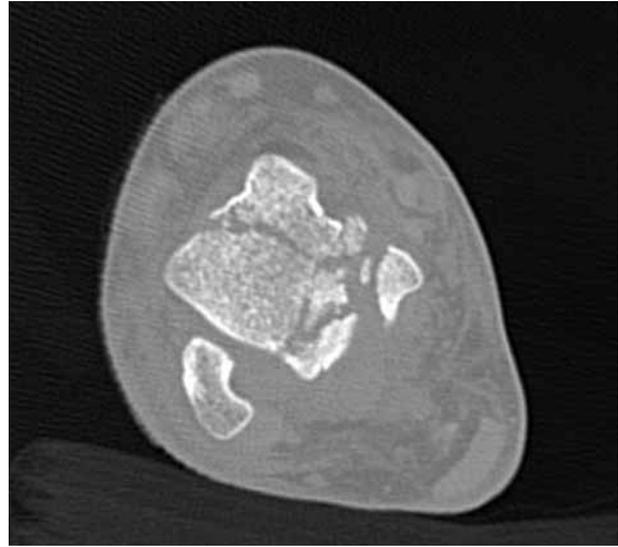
Transverse CT scan image of the injured talus. The fracture is comminuted and extends through the dome of the talus, but there is no gross displacement of the fracture fragments.
